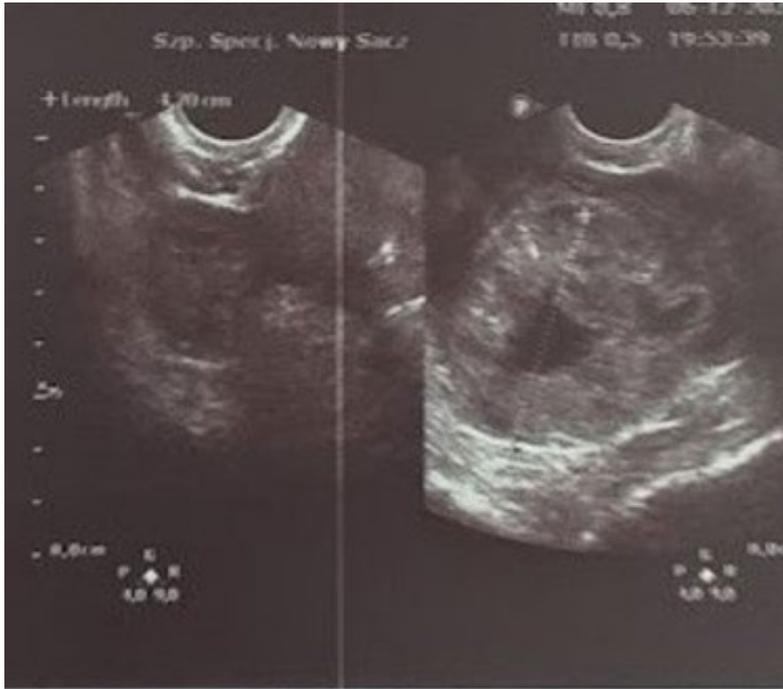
Transvaginal ultrasound B-mode scan of the left ovary. The nephrogenic mass with an echogenic outer ring of 4.7 cm in diameter in the left ovary. Pressure applied via the probe could not separate the mass from the ovary.
